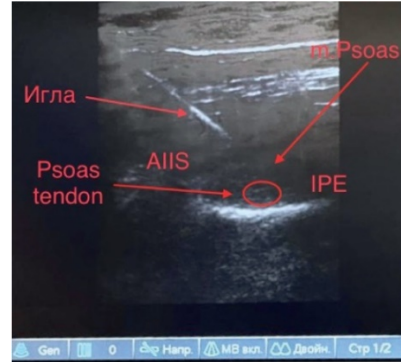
Anesthesia of the hip joint capsule using ultrasound
